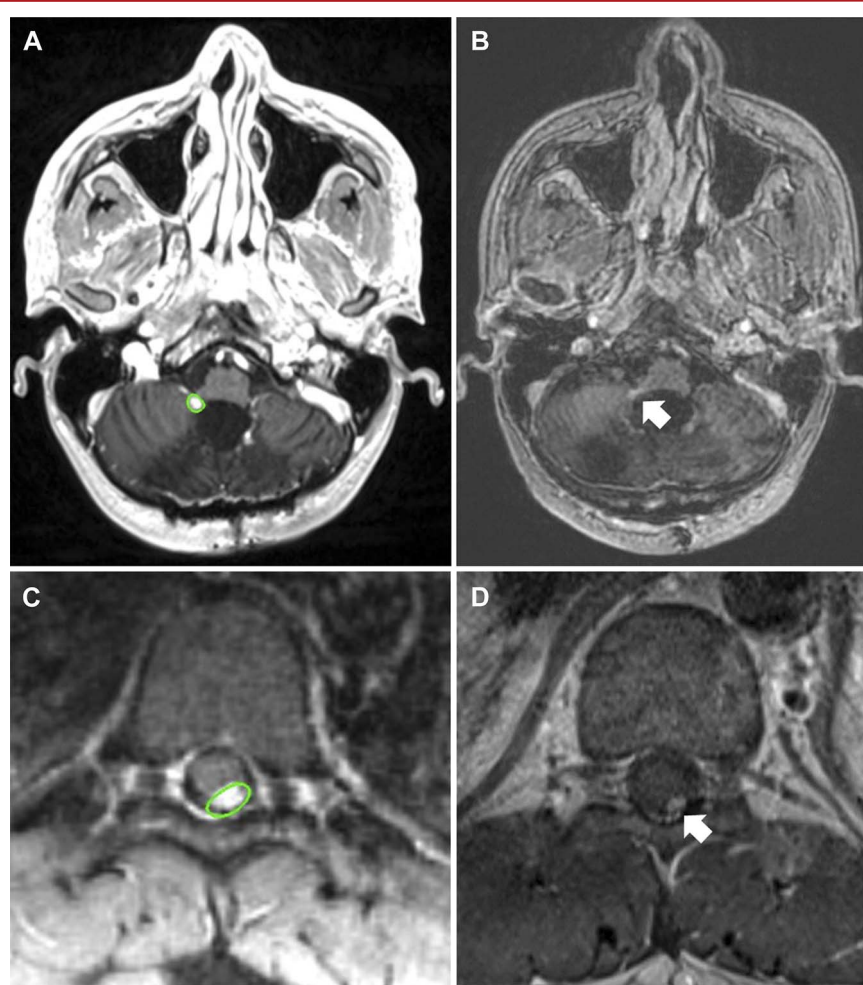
Comparison of baseline CyberKnife treatment plans and subsequent radiographic evaluations for patients with cranial and spinal ependymomas. A and B, The initial treatment plans and B and D, images from the most recent follow-ups. A and B, A 20-year-old male patient diagnosed with multiple recurrent grade 3 ependymoma (EP-PF-A) status post-multiple CyberKnife treatments for the cranial lesions, presented with a recurrent right cerebellar lesion during surveillance. A, A marginal dose of 27 Gy was delivered with the maximum dose of 35.62 Gy in 3 fractions to 76% of the isodose line. B, A substantial reduction in tumor size was evident in the 3-month follow-up MRI. C and D, A 21-year-old male patient with a history of multifocal myxopapillary ependymoma status postsurgical resection for thoracic and lumbar intradural ependymomas, presented with a new T8 spinal lesion during surveillance. C, He received CyberKnife treatment with a marginal dose of 24 Gy (maximum dose 32 Gy) in 3 fractions to 75% isodose line. D, A significant decrease in tumor size was observed, with consistent control over the tumor in the 12-year follow-up MRI.
